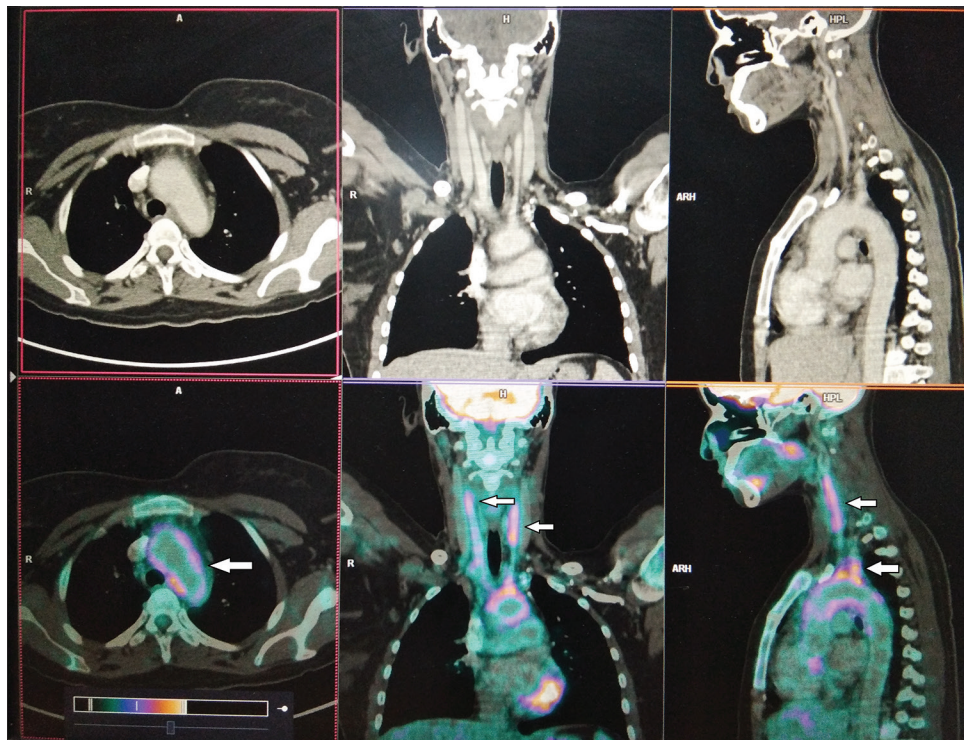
FDG PET CT scan of a patient with large vessel vasculitis. Diffuse FDG uptake is noted in the arch of aorta, bilateral carotid arteries, and the subclavian arteries
